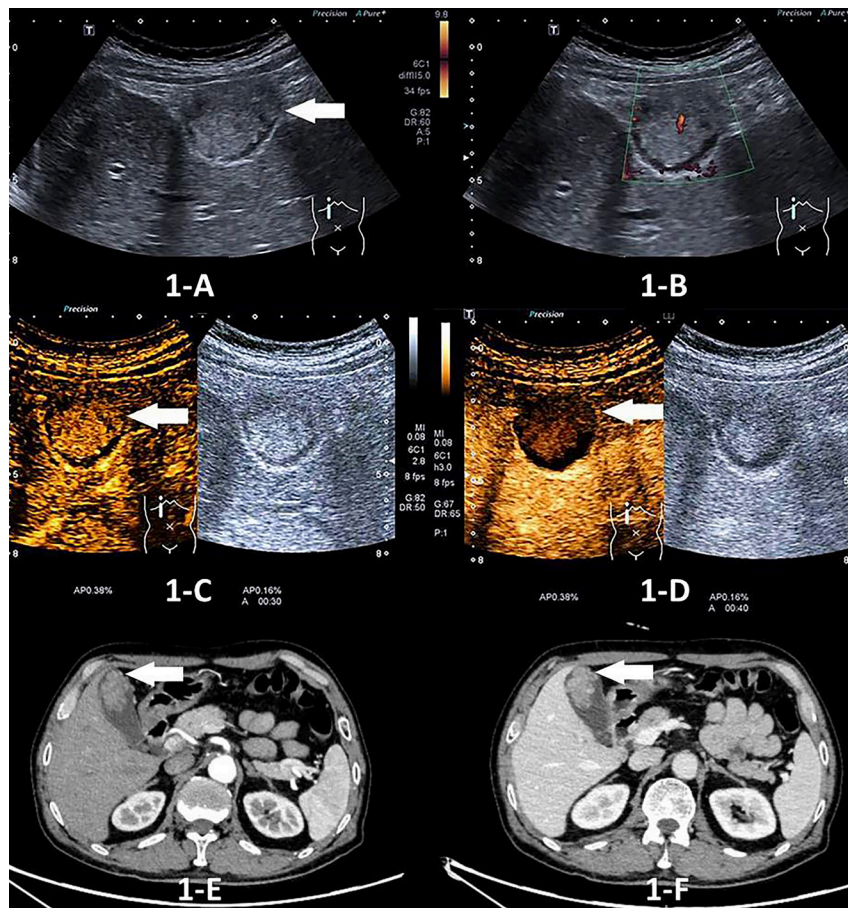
A 67-year-old man with a 26.3 × 16.6 mm GBC was diagnosed using CEUS and CECT. (A-B): A mildly hyperechoic lesion located in the fundus of GB (arrow) and power Doppler showed a few strip-like blood flow signals on conventional ultrasound. (C-D): The tumor was of heterogenous hyper-enhancement in the arterial phase (arrow) and washout at 40 s in the late phase (arrow) on CEUS. (E-F): The lesion was obviously enhanced in the arterial phase (arrow) and hypo-enhancement in the venous phase as compared to liver (arrow) on CECT.
